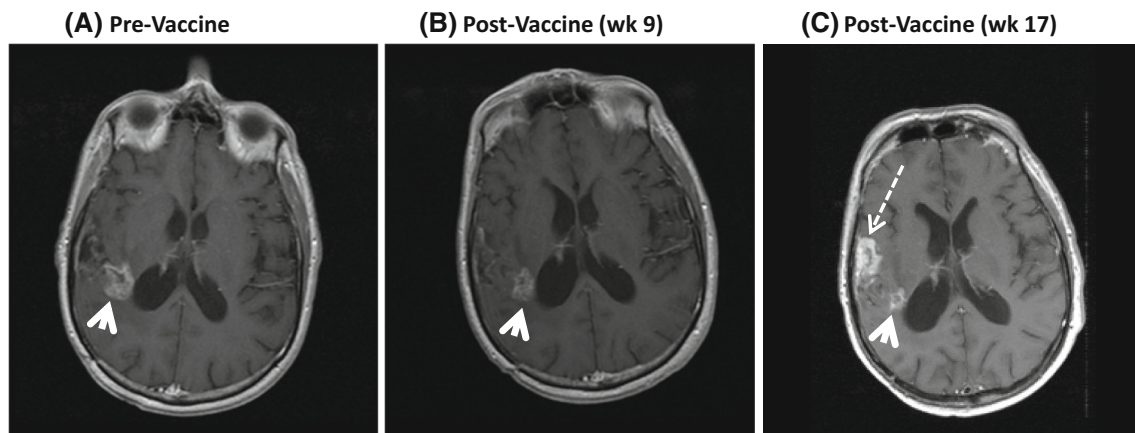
T1-weighted axial images following gadolinium administration in a patient with glioblastoma demonstrating pseudoprogressive changes after vaccination with autologous dendritic cells pulsed with glioma associated antigens and administered with poly-ICLC. a New nodular focus of enhancement in the medial right parietal lobe (*white arrowhead*) consistent with tumor progression prior to administration of vaccination. Note that the original tumor site which is located in the lateral right parietal lobe demonstrates minimal enhancement.
